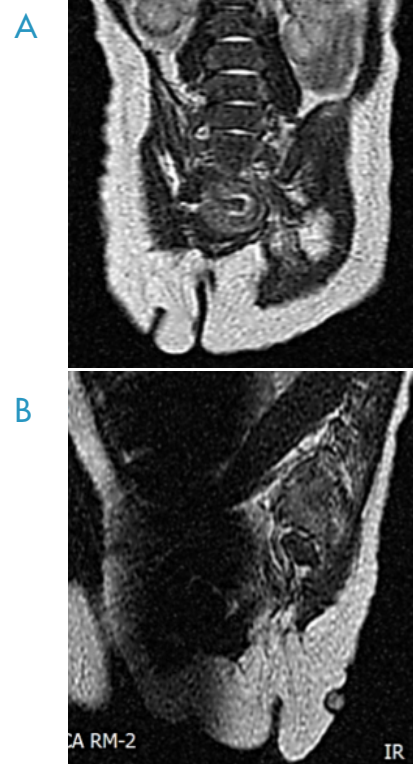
MRI of the lumbosacral spine.
